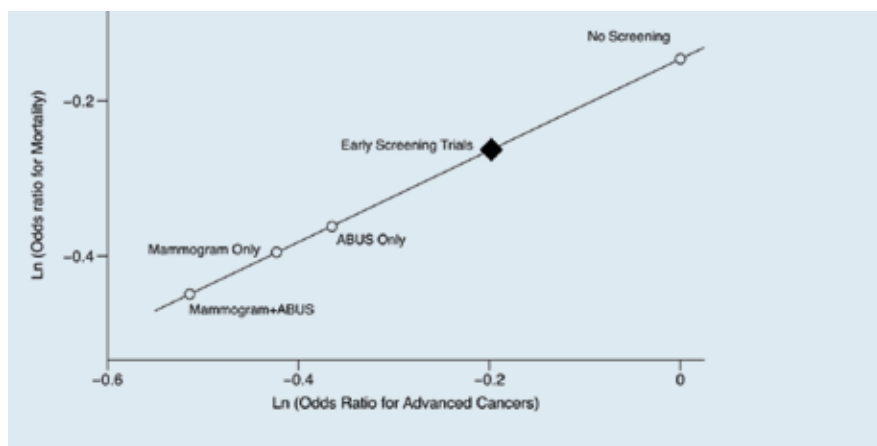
Ultrasound-based screening strategies compared to an aggregate of the early mammographic screening trials and to no screening.[13].
